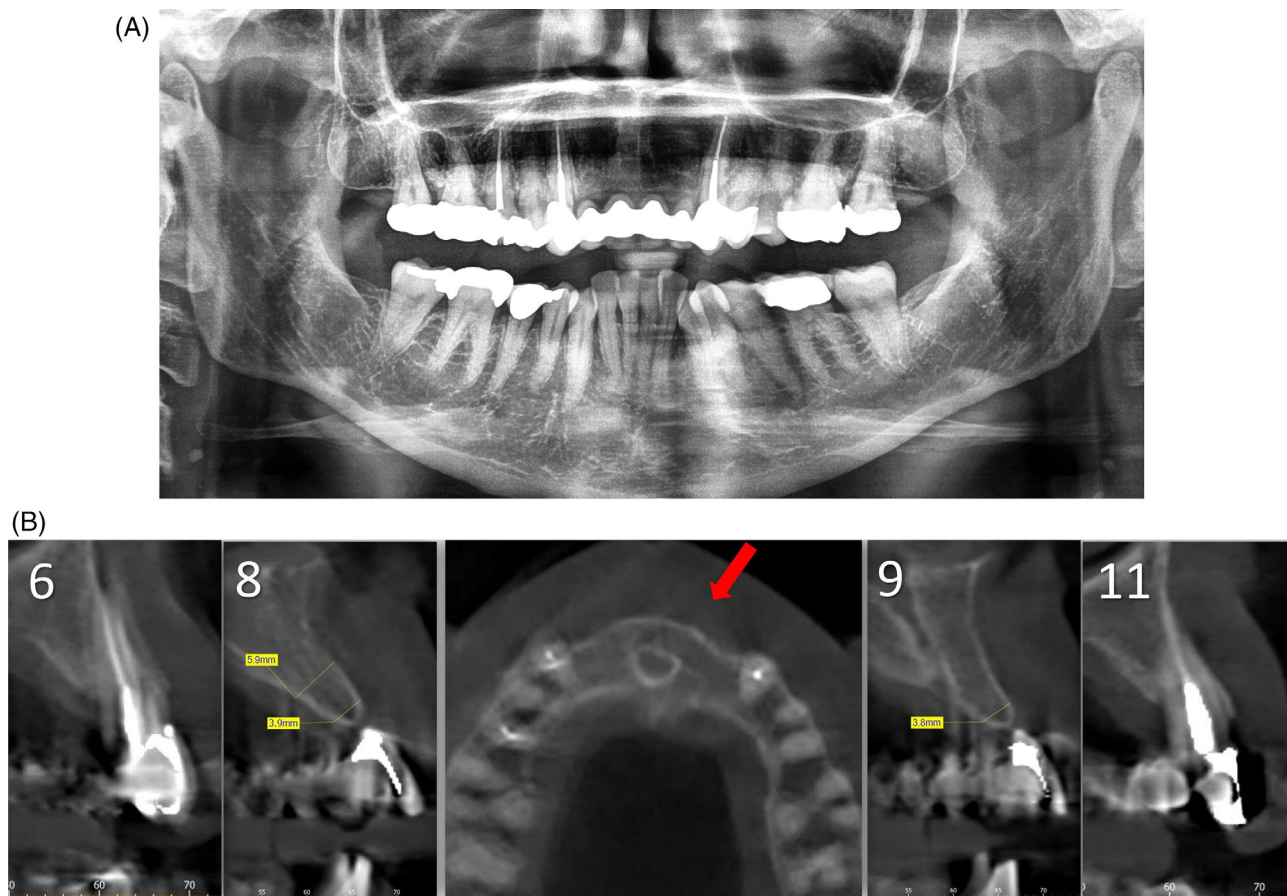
(A) and (B) Radiographic exam show adequate bone width and height for implant placement at sites # 6, 8, 9, 11 for two implant-supported bridge restorations
